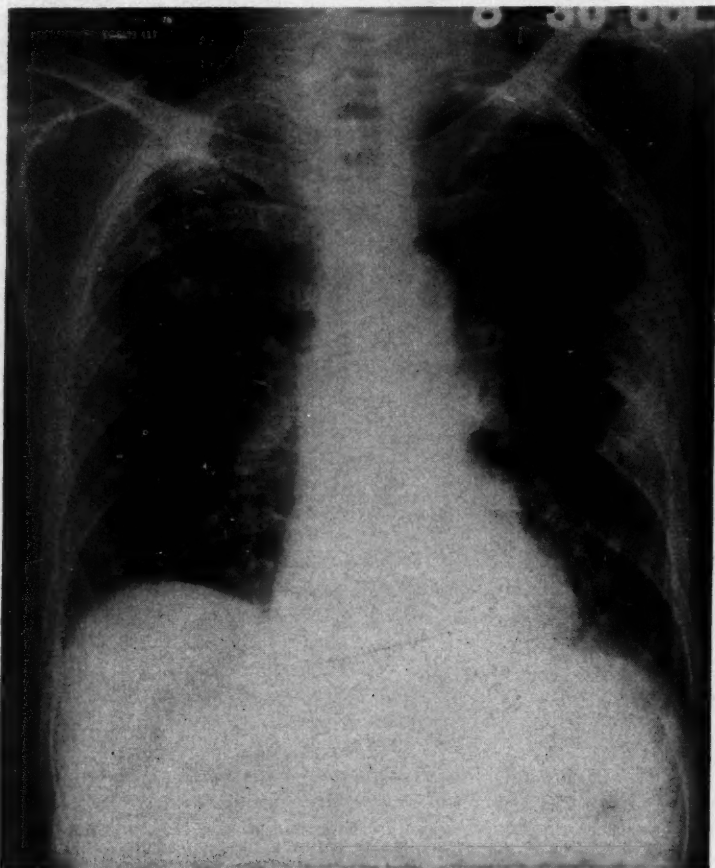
Roentgenographic appearance of the chest at the height of the reaction.
